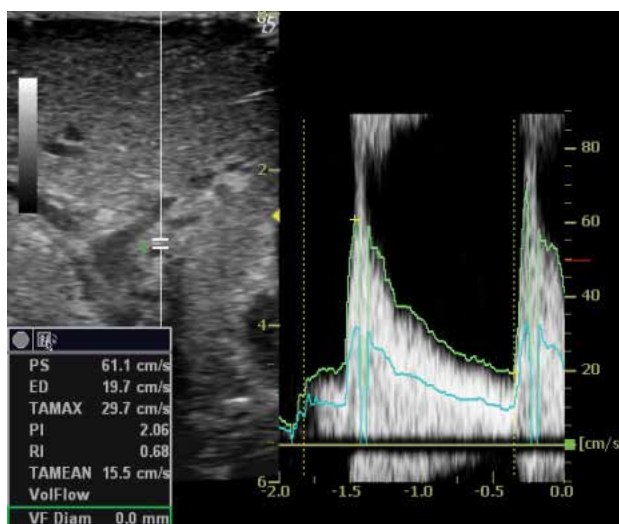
Doppler ultrasonography is used to detect the intact hepatic arterial flow in the graft liver
